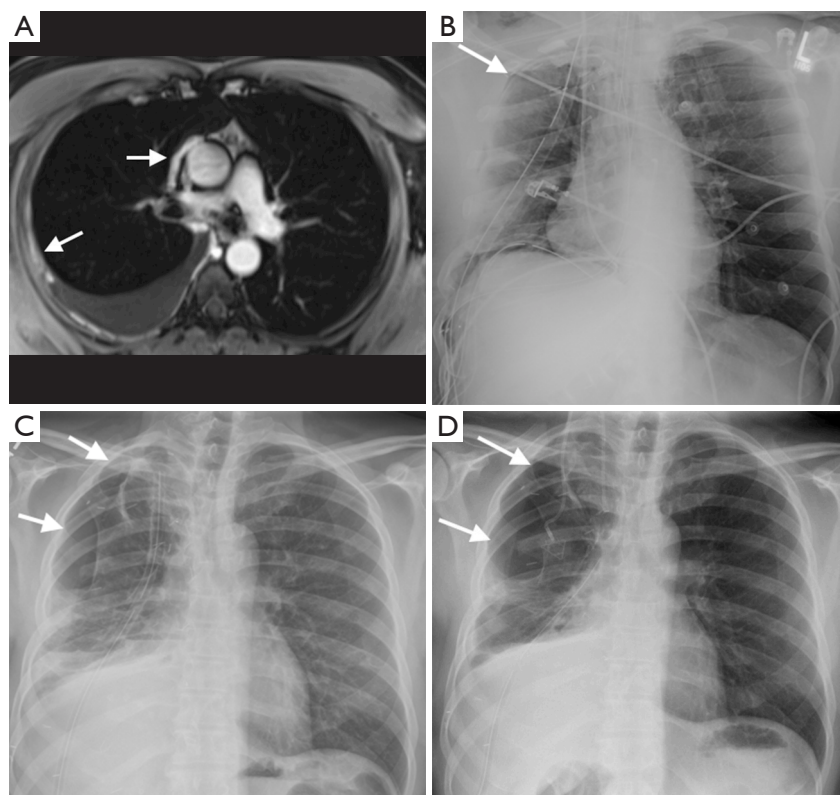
A 59-year-old man with right epithelioid mesothelioma. Axial T1 weighted fat saturated post gadolinium (A) from a preoperative MRI demonstrates multifocal, circumferential enhancing right pleural nodularity (arrows), with a small right pleural effusion. The patient underwent a right EP/D with diaphragmatic and pericardial reconstruction and multiple lung wedge resections. Day 1 post-operative CXR (B) demonstrates a small right pneumothorax (arrow) with three right-sided chest drains. CXR one-month post-op (C) demonstrates a persistent loculated right pneumothorax (arrows) consistent with a persistent air leak. The right pneumothorax persists on CXR 7 week post-surgery (arrows, D). MRI, magnetic resonance imaging; EP/D, extend pleurectomy/decortication; CXR, chest radiograph.
